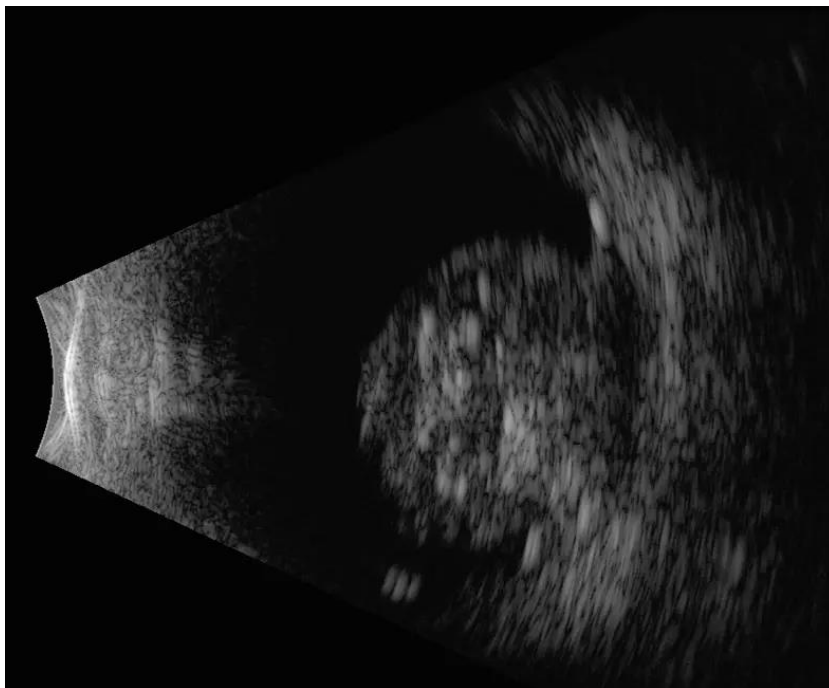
Retinoblastoma as visualized by B-scan ultrasound reveals a dome-shaped mass originating from the retina with intralesional calcification. (3)
